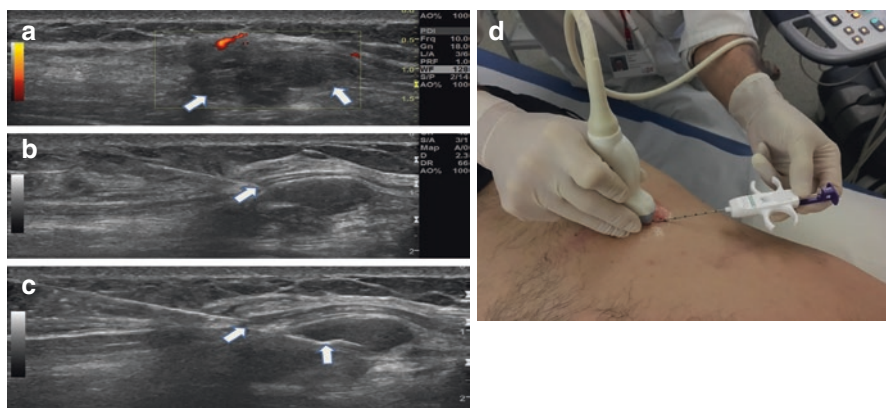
Male patient, 70 years old, known with lung carcinoma. Solitary soft tissue nodule at the thoracic wall, serratus anterior location, with extension into the intercostal area. Non-homogeneous hyperechoic vascularized mass lesion with maximal size of 2.2×0.9 cm is demonstrated on ultrasound (a, *arrows*). Safe needle orientation is planned in order not to stab vital structures even on accidental transfixation of the lesion (nerves, vessels, joint, and pleura of the lung). Loaded Tru-Cut needle tip with 10 G thickness is positioned in front of the lesion under ultrasound guidance (b *arrow* and d). Biopsy needle is advanced in the lesion without transfixation of the lesion (c). Demonstration of the biopsy load channel (c, *arrows*) with length of 2 cm in the lesion
